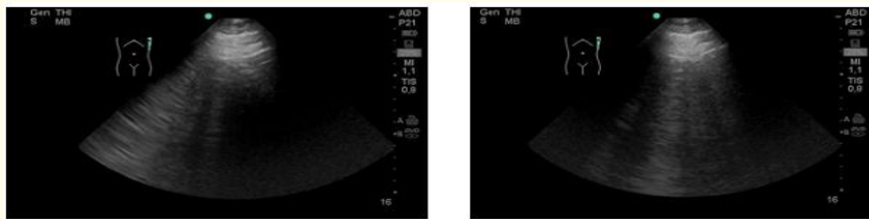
Transthoracic Lung Ultrasound Scan non coalescent B-lines, moderate loss of aeration. LUSS 1 (degree of loss of aeration).
